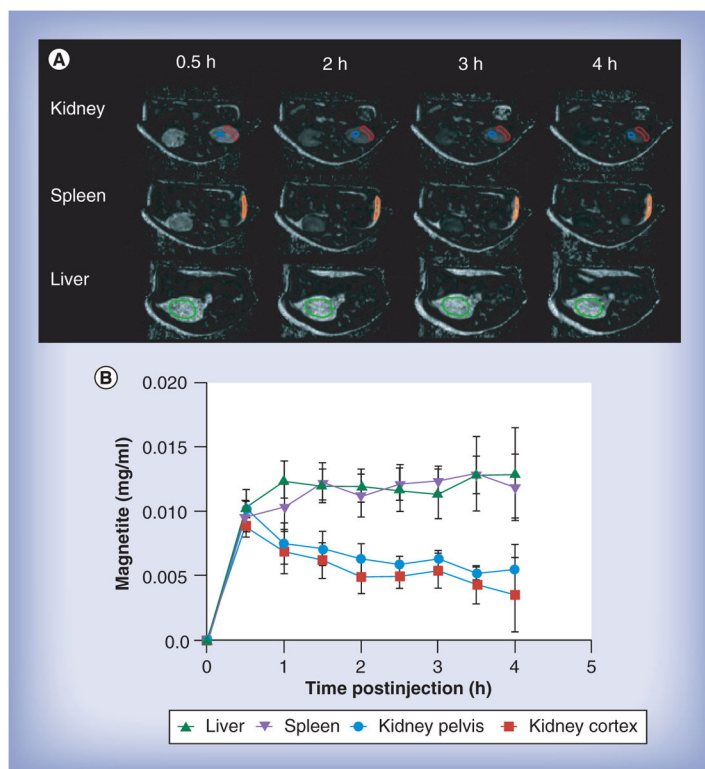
MRI assessments of the tissue drug biodistribution and pharmacokinetics by small magnetite antiretroviral therapy particles
